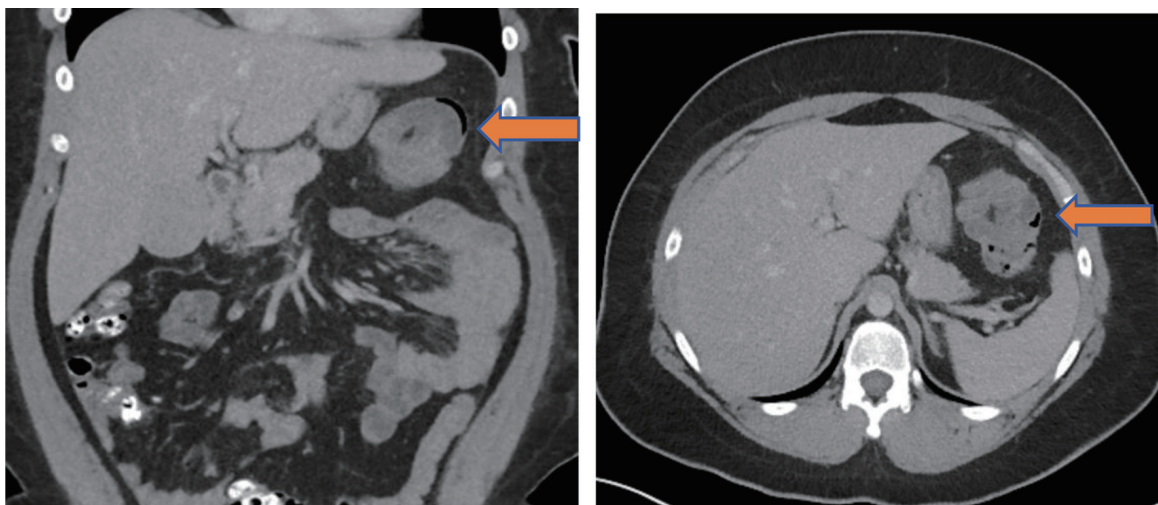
Follow-up computed tomography (CT) of abdomen/pelvis, coronal view (a) and axial view (b), demonstrating splenic flexure colocolic intussusception with a lead point indicated by blue arrows, showing low-attenuation bowel wall thickening with surrounding edema.
